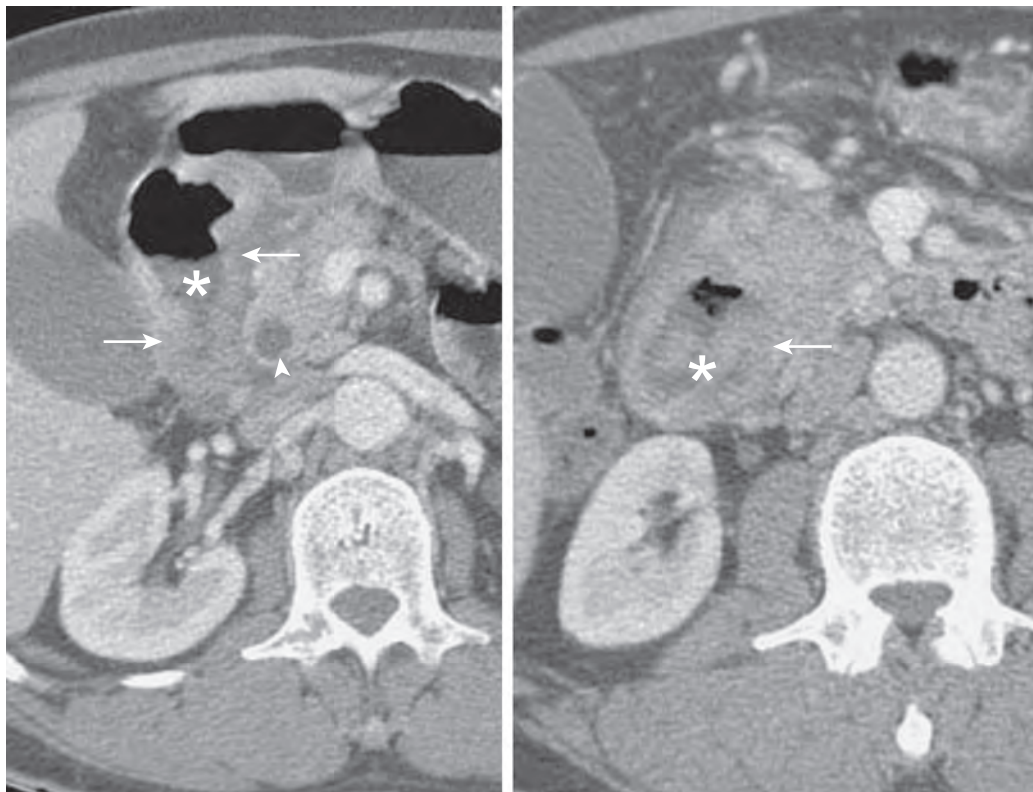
Duodenal lymphoma with exaggerated duodenal folds on CT. Sequential CT images in a patient with jaundice show deformity of the descending duodenum with a homogeneously thickened wall and thickened, exaggerated folds (arrows) caused by biopsy-proven non-Hodgkin's lymphoma. The duodenal lumen contains air and fluid (asterisks). Also note dilation of the common bile duct (arrowhead).
